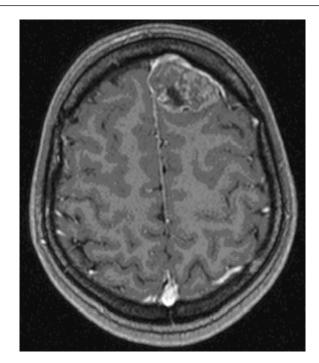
MRI; Post-Gadolinium transverse image revealed an ovoid shaped $3.9 \times 2.4 \times 1.5$, extra-axial, parasaggital, left anterior frontal mass.
